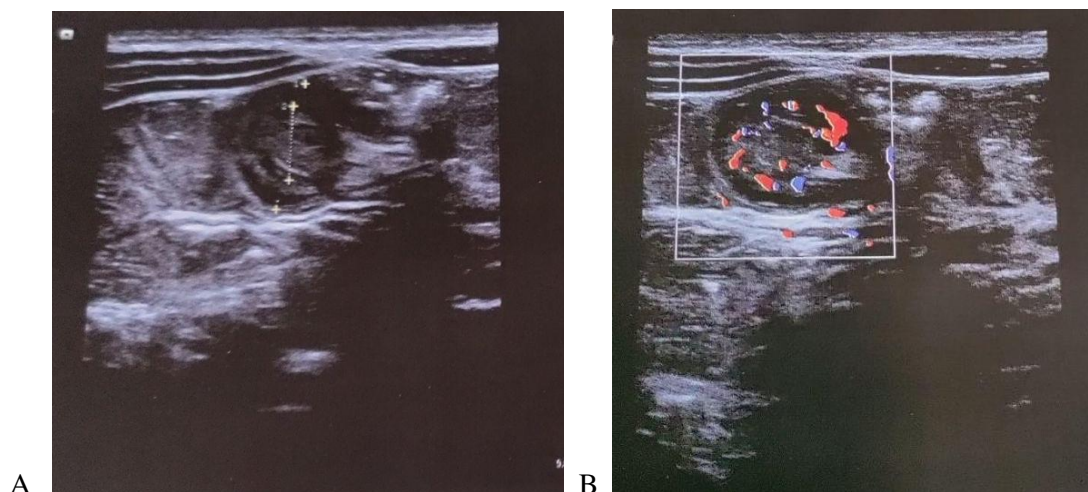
Abdominal Ultrasound images A. Classic ‘whirlpool sign’ confirmatory of intussusception, B. Doppler study showing vascularity
